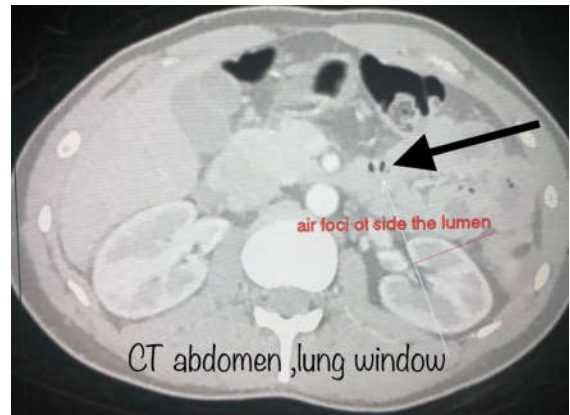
CT scan abdomen showed air foci outside lumen
